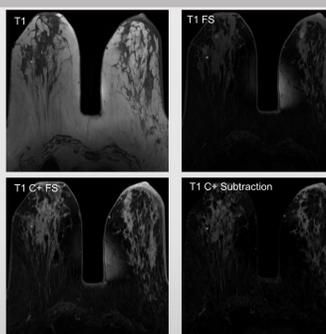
Right Breast Mass MRI Correlate . Breast CE-MRI demonstrates an irregular, heterogenous, T1 intermediate mass exhibiting avid enhancing on post-contrast images (asterisks). Biopsy results were consistent with complex sclerosis / ADH.
